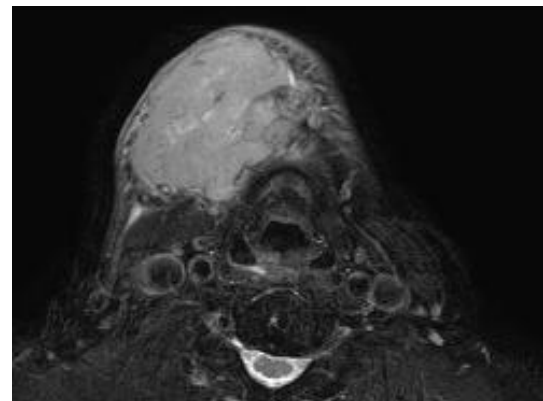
Axial image of MRI.
